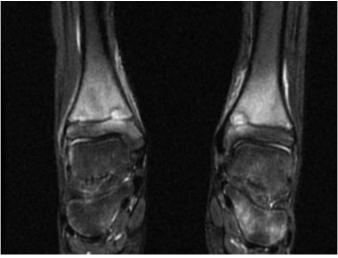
MRI showing diffuse bilaterally STIR hyperintense marrow edema in distal metaphysis of both tibia
